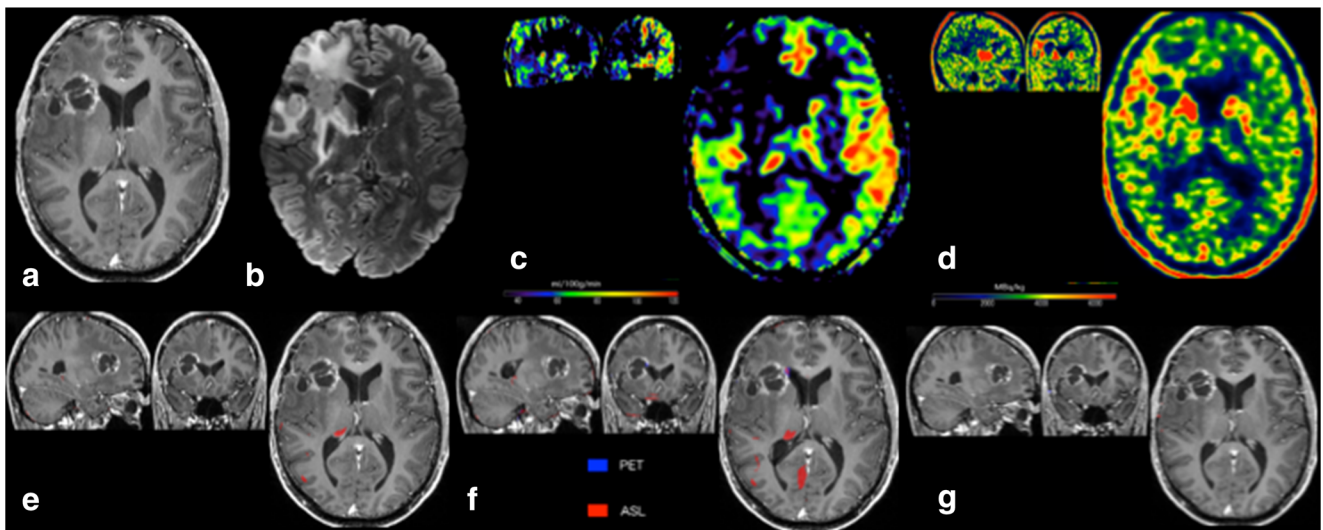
PET-MR of a 40-year-old male patient with a right-sided glioblastoma WHO IV with IDH mutation, treated by surgery and adjuvant radiotherapy. Pseudo-progression was confirmed by the follow-up (true negative for ASL and PET). Upper row: a Linear cavitory enhancement observed at the initially treated frontal lesion site on a contrast-enhanced axial T1-w image. b Axial FLAIR-w image. c The absence of hyper-perfusion as assessed by CBF on ASL images (rCBF: 0.58). d A
